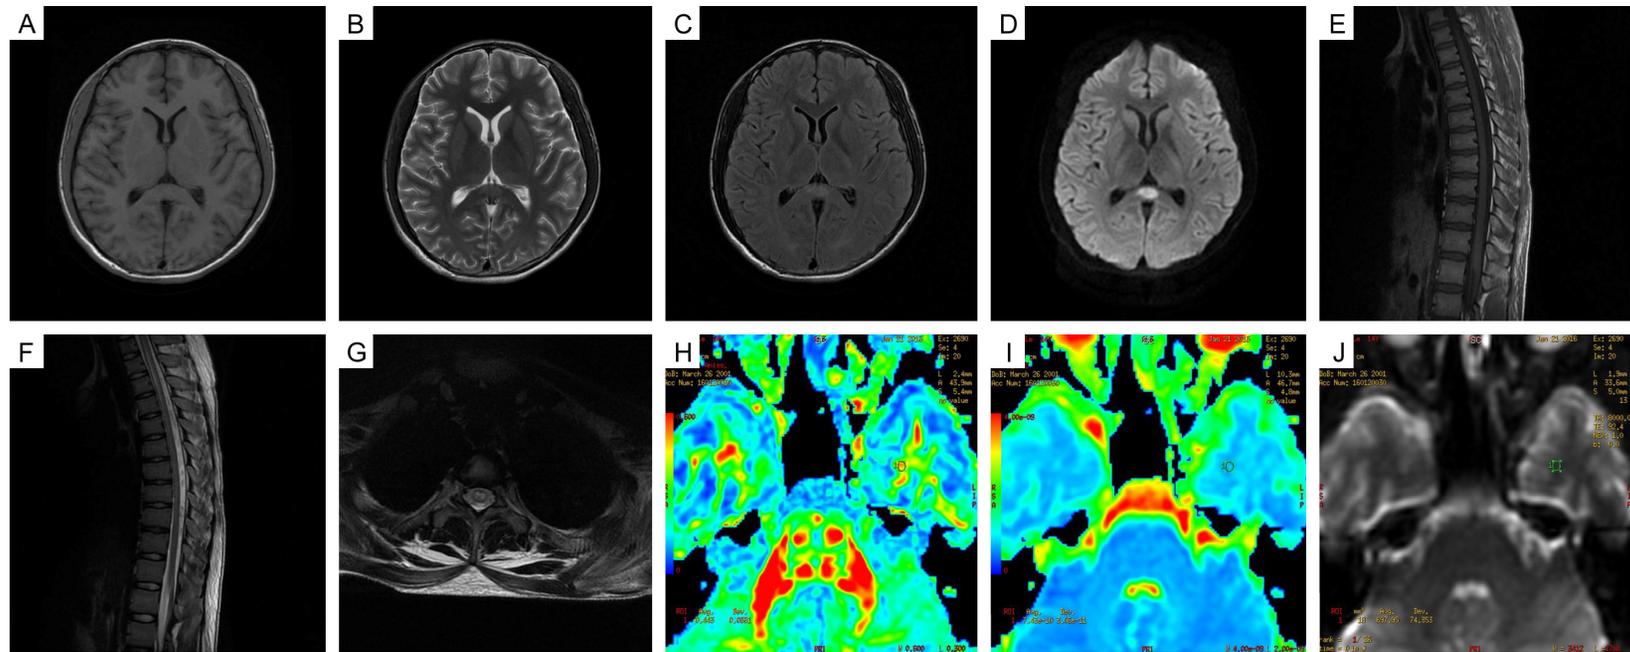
Magnetic Resonance Imaging Scans (3.0T) after his clinical conditions worsened. The lesions of SCC (A-D) and spinal cord (E-G). The DTI showed reduced FA in the SCC (H-J).
